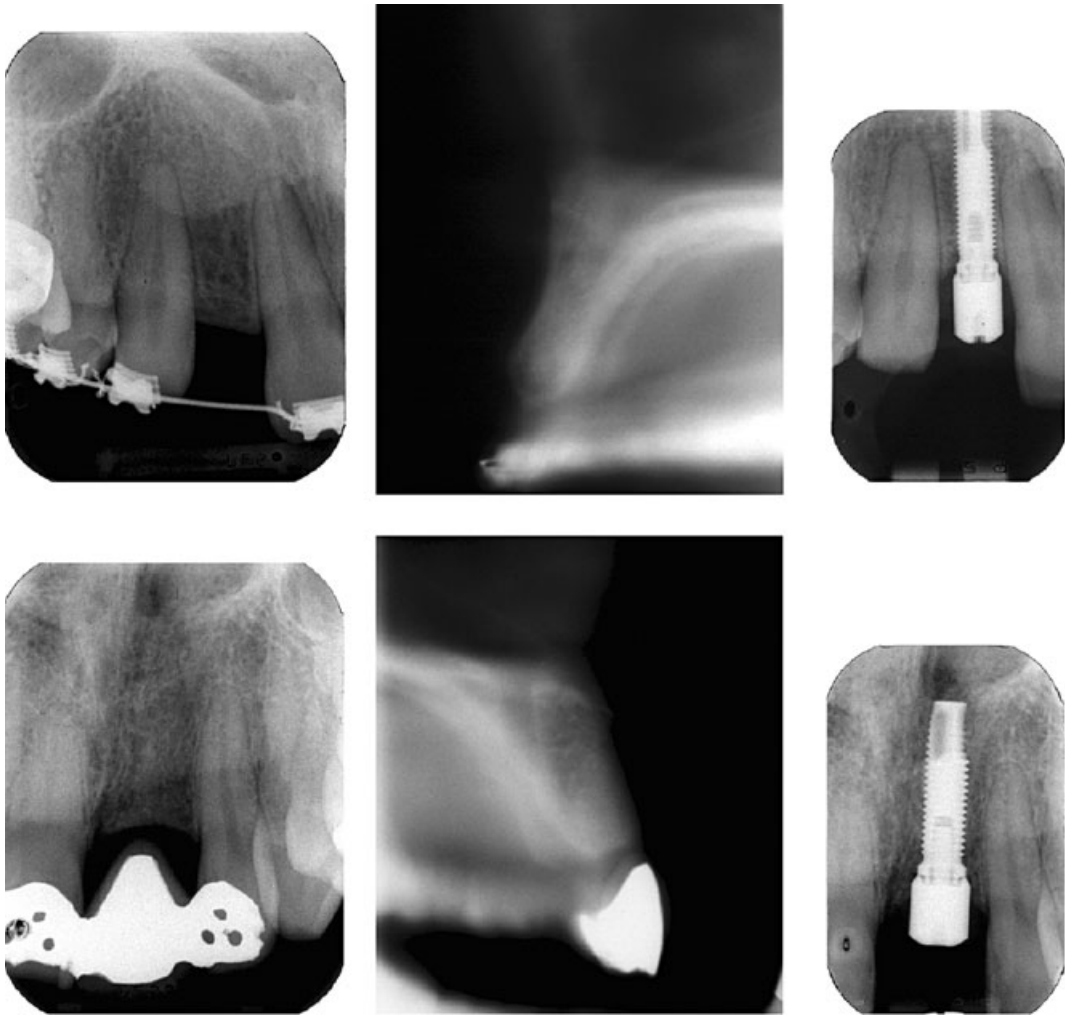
Two cases of missing upper incisors in which the pre-operative radiographic examination was made by intraoral radiographs and conventional spiral tomography. In the lower row case an implant could be placed buccal to the nasopalatine canal.
